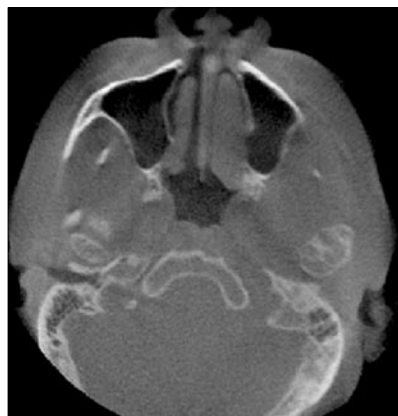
CBCT of an osteochondroma in the left TMJ (axial view). Note the irregular condylar bulbous or globular expansion (courtesy of USC Redmond Imaging Center).
